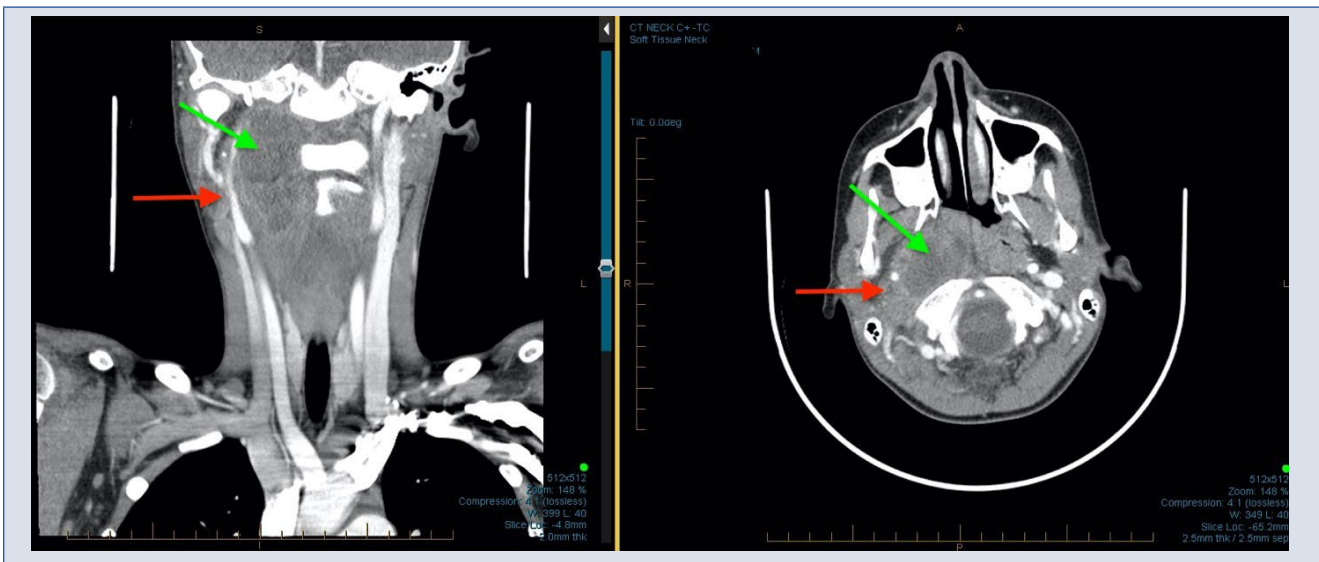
Computed tomography angiogram of the patient showing a large retropharyngeal abscess (green arrow) with acute thrombosis of the right intrajugular vein (red arrow)
